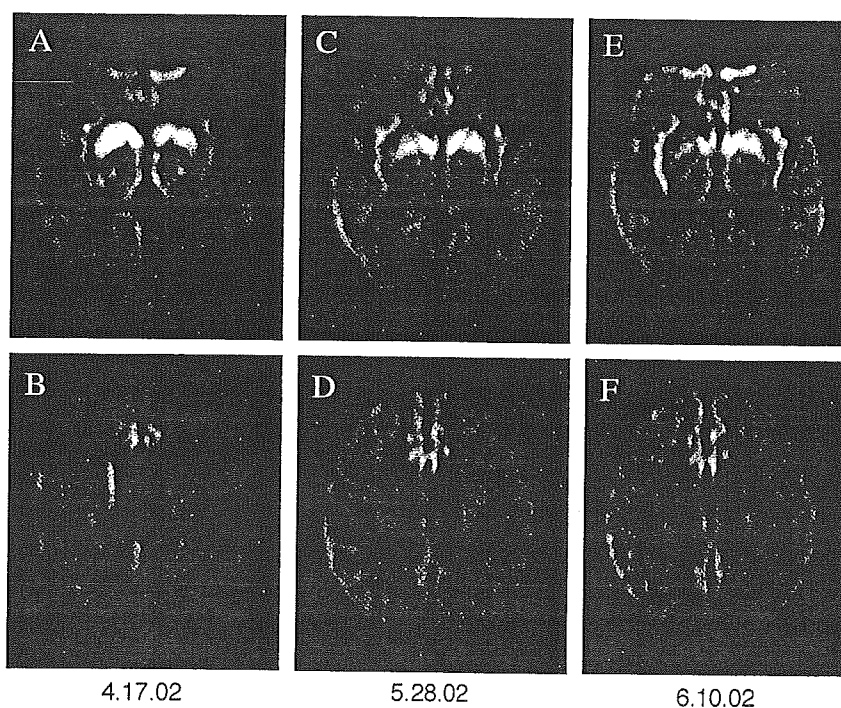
Magnetic resonance imaging of the brain of a patient with familial Creutzfeldt–Jakob disease, performed with serial diffusion-weighted images (DWI). (A) and (B) were performed at admission to hospital, (C) and (D) at approximately 1 month, and (E) and (F) at 2 months after admission. (A) and (B) High signal intensity bilaterally in the basal ganglia, insula, and cingulate gyrus. (C) and (D) Slightly decreased hyperintense bilateral signals in the basal ganglia; extension of signals in the cortex into left temporoparietal cortex and cingulate gyrus. (C) Increased signal intensity in areas of hyperintensity in insular cortex. (E) and (F) Slight decrease in hyperintense signals in cingulate gyrus, insular cortex, left temporoparietal cortex, and basal ganglia.
